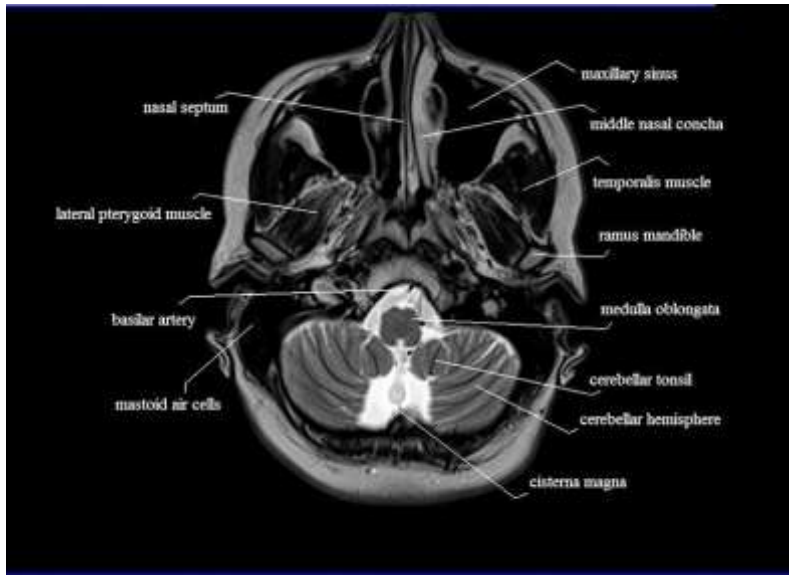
Axial MRI anatomy; T2-WI above level of foramen magnum
